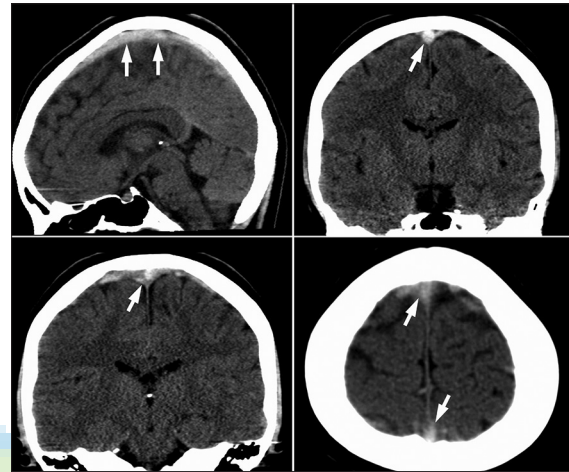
Nonenhanced computed tomography of head showed increased attenuation in superior sagittal sinus (arrows) which indicates the cord sign
